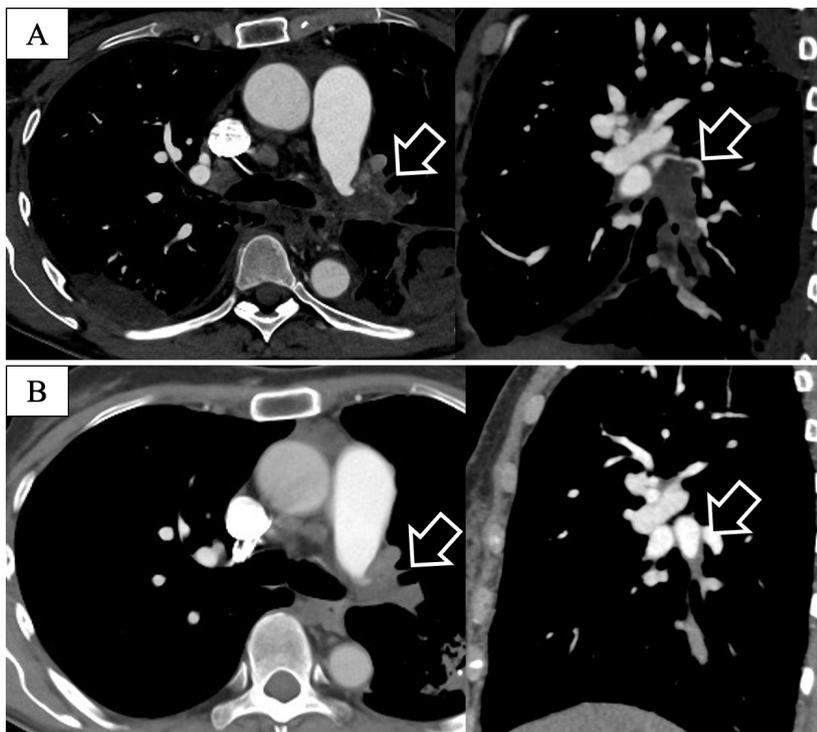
Enhanced computed tomography images showed thrombus in the left pulmonary artery bifurcation (left arrow) and in the right common basilar artery bifurcation (right arrow) on the 12th day of the second admission (A). The thrombus in the left pulmonary artery remained unchanged (left arrow), but the thrombus in the right basilar pulmonary artery has almost disappeared (right arrow) six months later from the initial admission (B).
